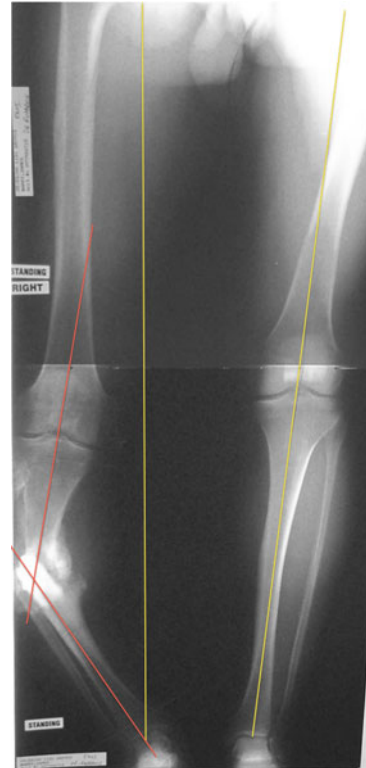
Pre-operative standing 51" erect leg radiograph. Mechanical axis deviation (*MAD*) on the *right* was 78 mm medial to *midline*; *left* was 0 mm (*yellow lines*). The center of rotation of angulation (*CORA*) was at the obvious tibial nonunion site (*red lines*), and its magnitude was 40° of varus
